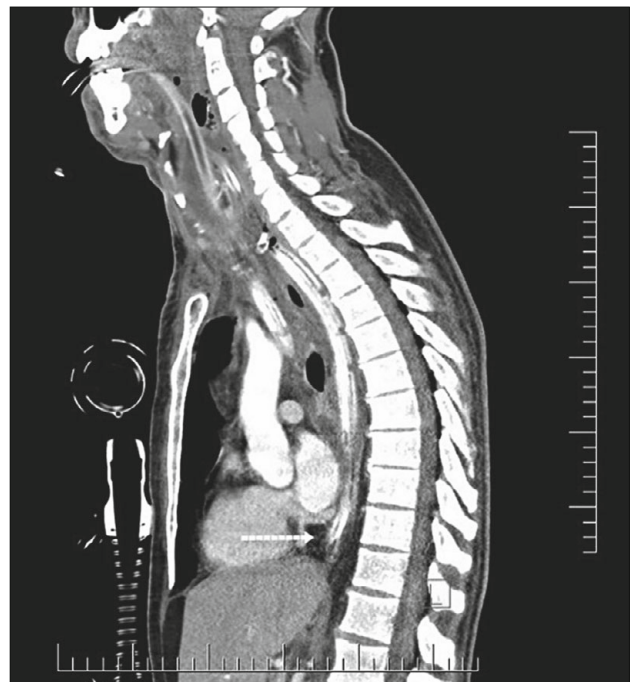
Computed tomography scan of the patient with Endo type IIB descending necrotising mediastinitis after surgery. Tip of the mediastinal drain placed in the prevertebral space (white dotted arrow).
